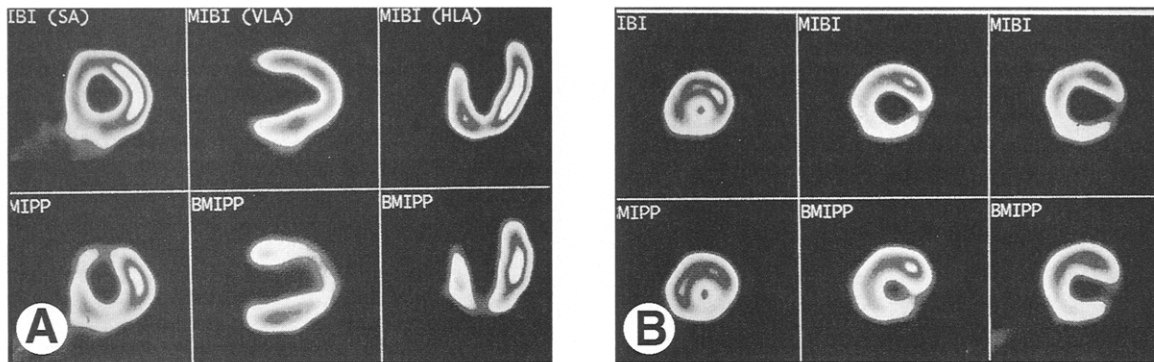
(A) Example of mismatched defects. Sestamibi (MIBI) and BMIPP obtained in a patient with left ventricular dysfunction 1 week after acute anterior myocardial infarction. The study shows reduced BMIPP but normal sestamibi uptake in the infarct-related coronary artery territory, indicating the presence of viable but jeopardized myocardium. HLA images are shown apex down. (Reprinted with permission.⁵³) (B) Sestamibi (MIBI) and BMIPP left ventricular short-axis slices obtained in a patient with recent acute inferolateral myocardial infarction. There is a mild-to-moderate mismatched defect of both tracers in the infarct-related coronary artery territory, suggesting the absence of residual viability. Regional dysfunction did not improve after revascularization of this patient. (Reprinted by permission of the Society of Nuclear Medicine from: Knapp F, Franken P, Kropp J. Cardiac SPECT with iodine-123-labeled fatty acids: evaluation of myocardial viability with BMIPP. *Journal of Nuclear Medicine* 1995;36:1022-1030.)
